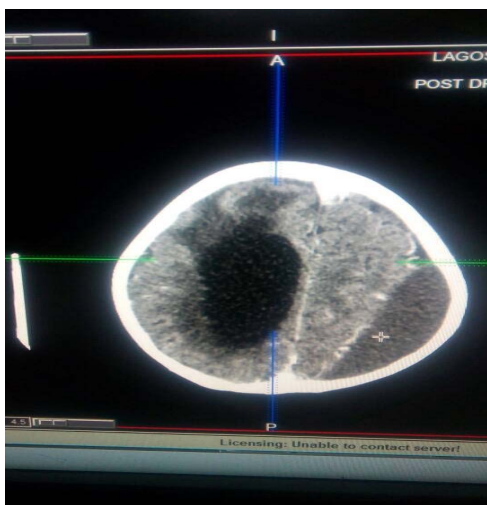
Brain CT scan showing a left sided extra-axial crescentic shape chronic subdural haematoma in a 68-year old who has trivial fall
